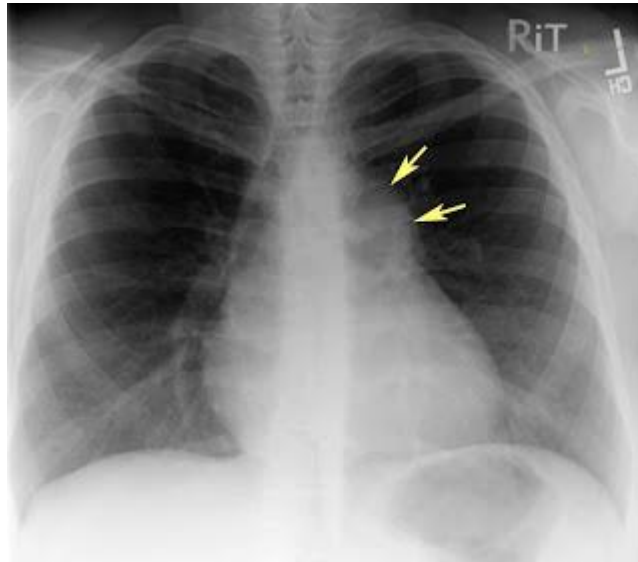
Chest radiograph reveals dilatation of the main pulmonary artery with relatively normal-sized right and left pulmonary arteries.⁽¹⁴⁾
